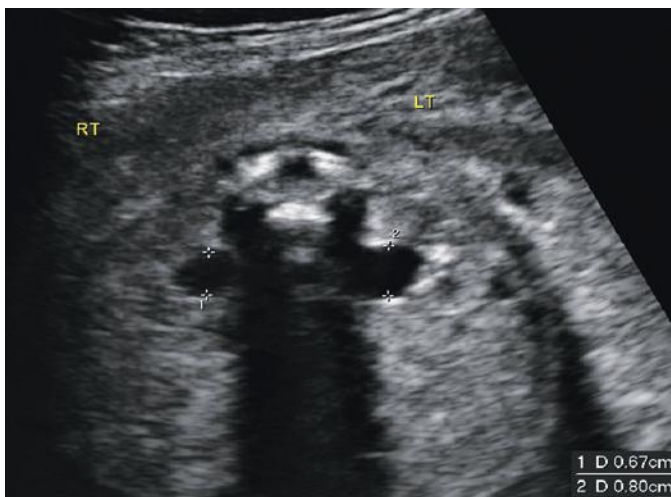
Transverse view of the fetal kidneys at the midtrimester; ultrasound image demonstrates mild bilateral pyelectasis. The anteroposterior diameters of the renal pelvis measure 0.67 and 0.80 cm on the right (RT) and left (LT), respectively.
